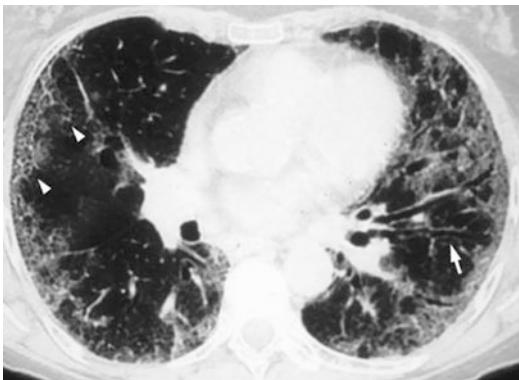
Chest CT findings of idiopathic pulmonary fibrosis. *White arrowheads* denote peripheral reticular opacities, while *white arrow* denotes traction bronchiectasis (Image courtesy of Dr. Stanley Siegelman, Department of Radiology, Johns Hopkins University)
